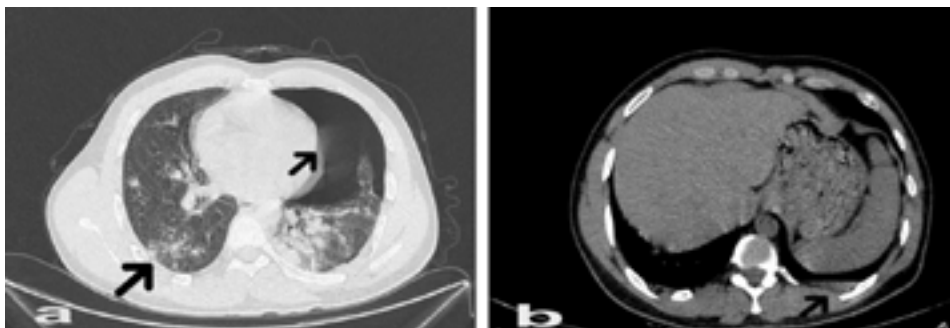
Chest computed tomography shows a) Pronounced air between the pleural leaves in the left lung (pneumothorax), compression collapse in the pulmonary parenchyma, and minimal pleural effusion in the basal region and b) Marked pleural effusion in the left lower lobe posterior basal segment
